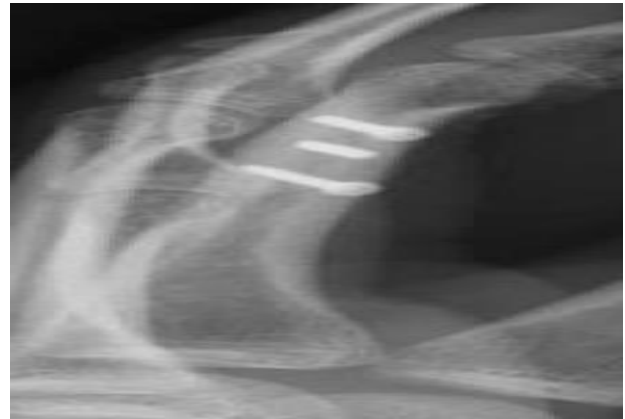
2 weeks post-operative lateral radiograph demonstrating maintained alignment.
